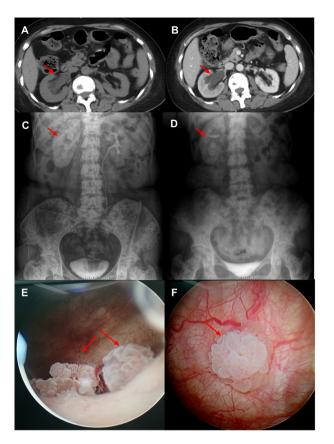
Patient images upon initial diagnosis of bladder metastasis. (A and B) Abdominal computed tomography revealed a dilated and hydrone-phrotic right renal pelvis, calyces and an upper ureter with thickened walls (arrow). (A) Non-contrast CT scan. (B) Contrast-enhanced CT scan. (C and D) Right renal dysfunction was detected via intravenous pyelography. (C) Pelvis and calyces of the right kidney were not visible during the excretory phase (arrow). (D) Post-excretion period showed a contrast fluid level in part of the renal pelvis in the right kidney (arrow). Cystoscopy revealed two lesions in the bladder wall, as shown by arrows in (E), the larger of which was 1.2x0.8 cm² as shown by arrow in (F).
